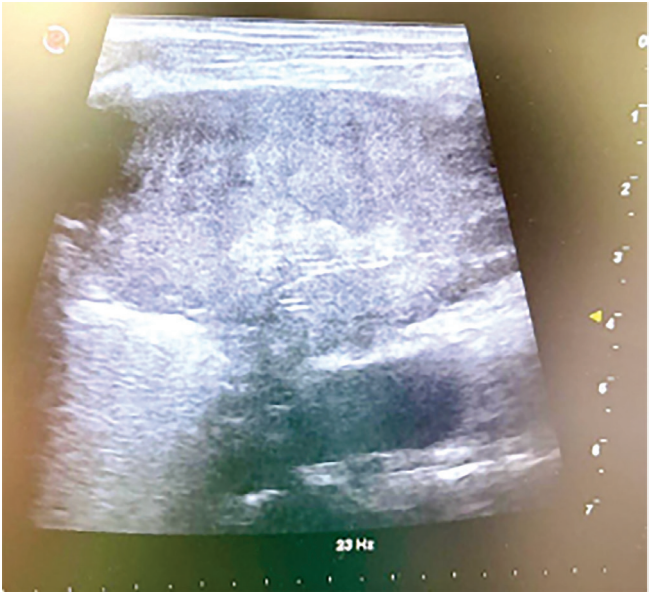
Ultrasound showing pleural-based hyperechoic shadow suggestive of a lung mass
